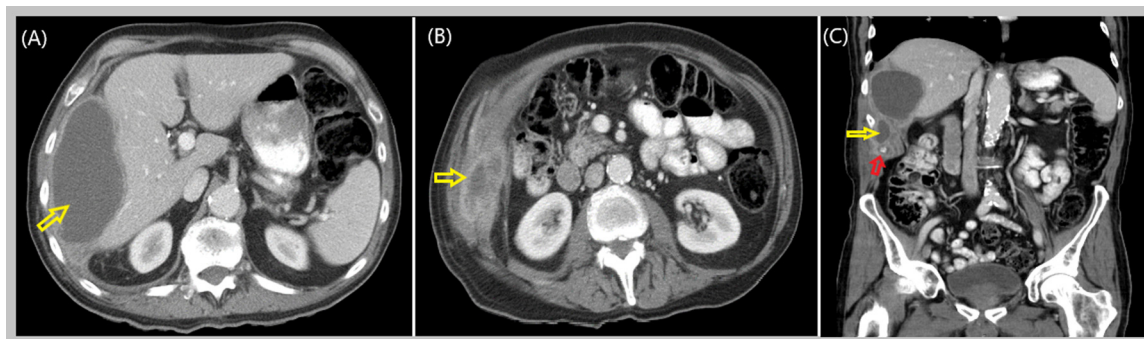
Abdominal wall fluid accumulation (abdominal CT). Very large fluid accumulation (yellow arrow in [A] and [B]) in the right upper quadrant lateral to the liver, measuring 12 × 6 × 9 cm, with an irregularly thickened wall as seen on Contrast-enhanced computed tomography. A second thick-walled loculation of fluid extends more inferiorly and laterally to the mid kidney level (yellow arrow in [C]). The second thick-walled collection measures approximately 6 × 4 cm and is located in the right paracolic gutter, lateral to the right colon containing a small focal indeterminate calcification (red arrow in [C]) with no presence of air or gas within the fluid (Color version of figure is available online).
